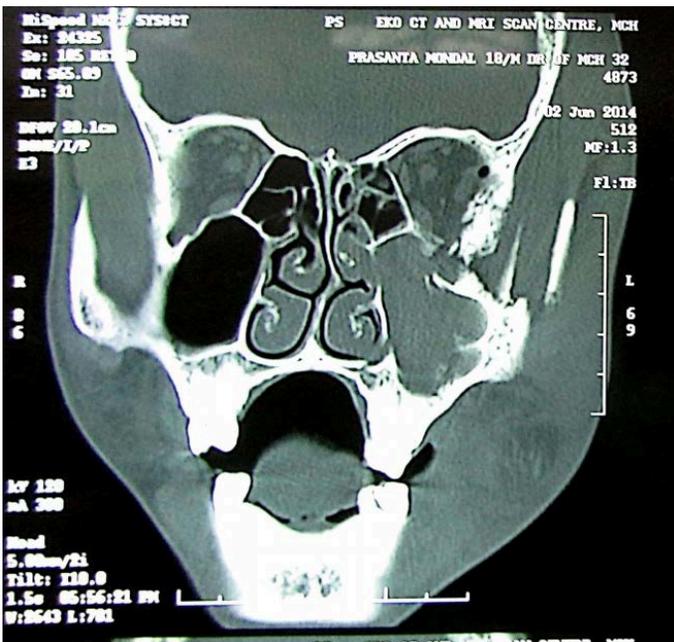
CT Scan of the patient
